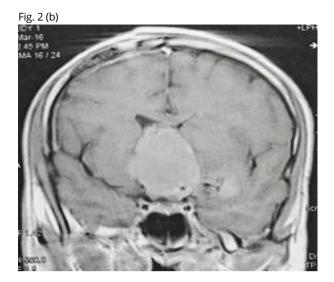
Preoperative MRI image of suprasellar tumor sagittal view (a), coronal view (b), postoperative follow-up MRI images sagittal view (c), coronal view (d).
